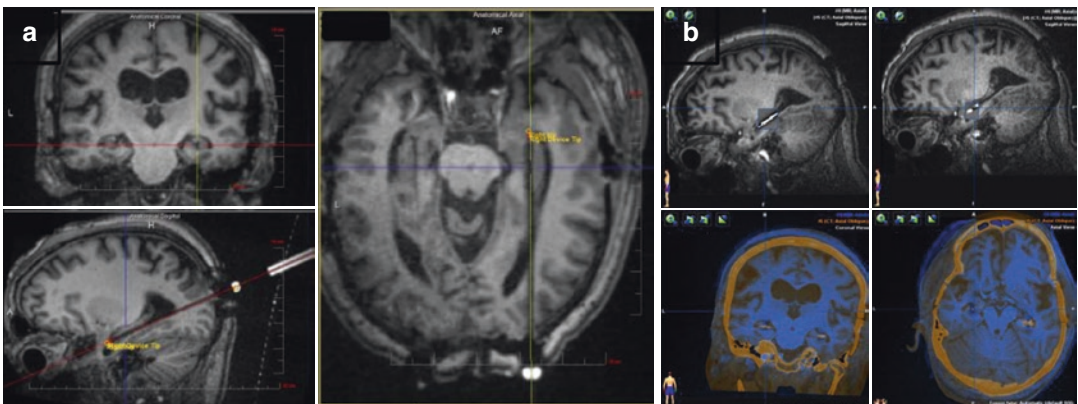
The use of the ClearPoint® system and intraoperative MRI for direct image-guided placement of RNS depth electrode arrays to the bilateral MTL structures (hippocampus and amygdala). (a) Intraoperative MRI
